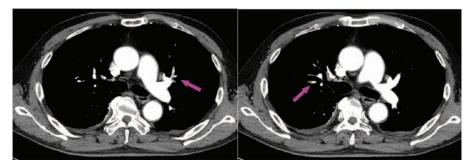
On the cross-sectional CT images, the purple arrows indicate embolic defects in the peripheral branches of the bilateral pulmonary arteries. CT = computed tomography.
